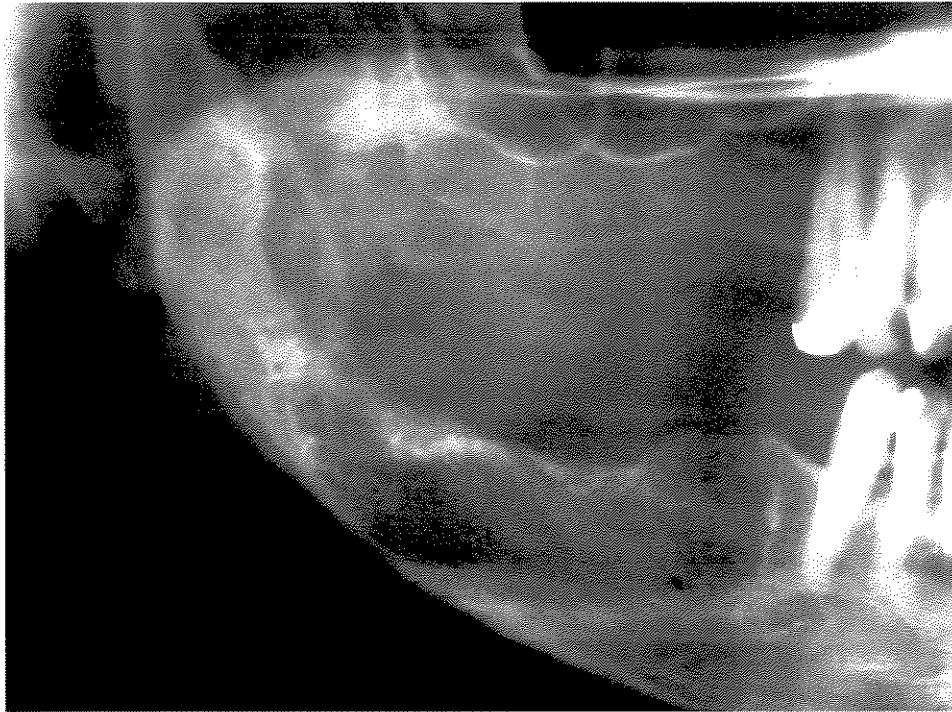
Panoramic radiograph of case 2 showing an irregular radiolucent area in the right mandibular body and ramus, that proved to be a recurrent central low-grade mucoepidermoid carcinoma.
